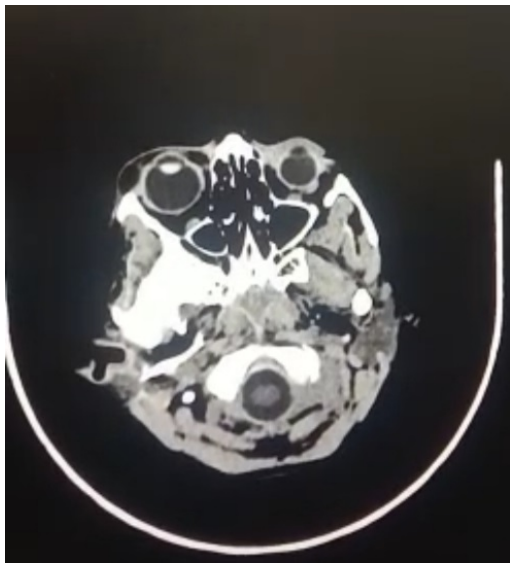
CT Axial section
